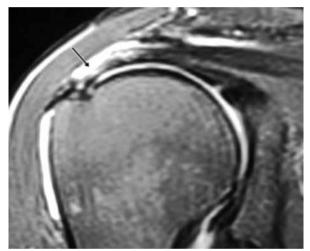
Pre-operative MRI of the right shoulder. Coronal slide shows edema in subacromial bursa and partial tear in supraspinatus tendon.
